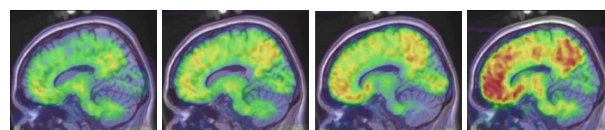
Three example cases of ¹¹C PiB PET overlaid on the Colin atlas *left* Healthy elderly *middle left* mild cognitive impaired *middle and far right* Alzheimer's. Note: These are obtained by co-registering the subjects ¹¹C PiB PET and MR images, the subjects MR is then affinely and non-rigidly warped to the Colin atlas, with the obtained transforms applied to the subjects ¹¹C PiB PET image.
